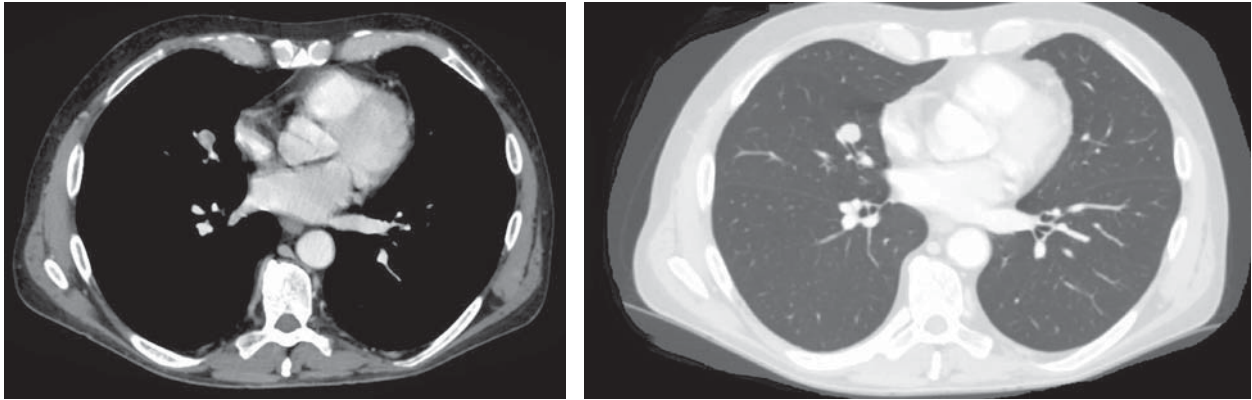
CT scan showing the middle lobe nodule
